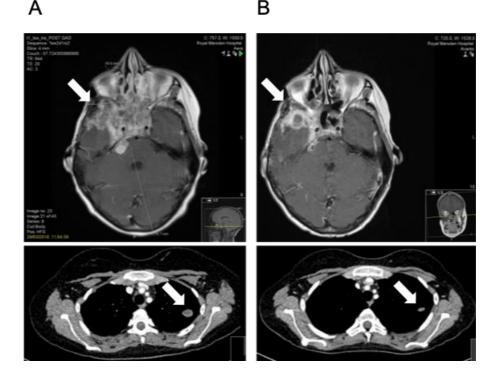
Magnetic resonance imaging (MRI) from patient with metastatic ameloblastic fibroodontosarcoma. MRI showing of the tumour (A) before and (B) after 8 weeks of BRAF inhibitor treatment. A reduction of primary tumour is seen in the skull base (top) and the pulmonary metastases (bottom). Tumour areas are highlighted by white arrows. Image kindly provided by Dr Sally George.
